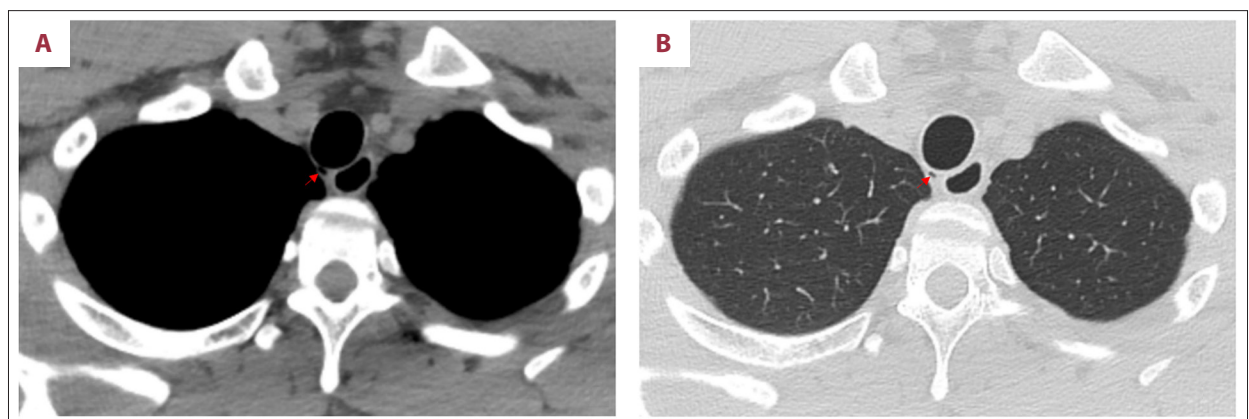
Computed tomography scan reveals a tracheal diverticulum located at T1 level, on the right posterolateral region of the trachea (red arrow points to the tracheal diverticulum). (A) Mediastinal window, (B) Pulmonary window.
